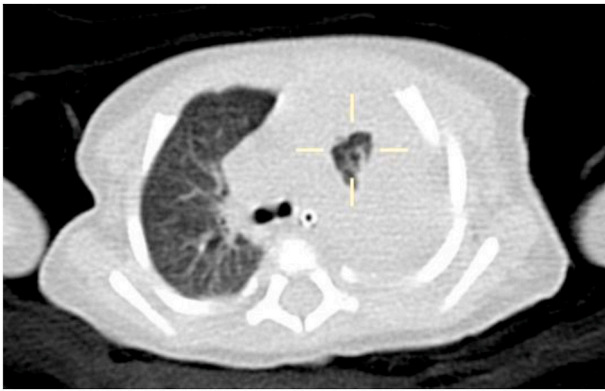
Chest CT scan, 15th hospital day.
